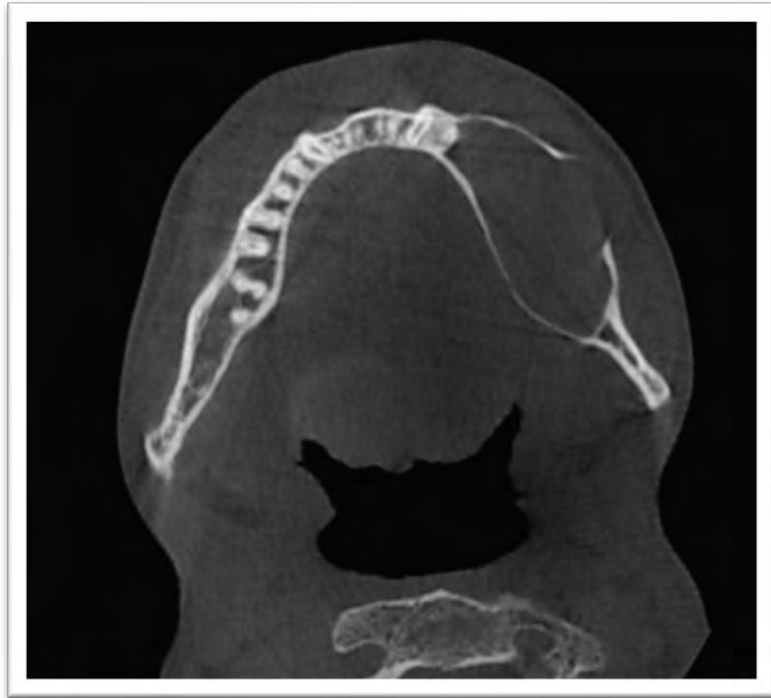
CT scan -preoperative showing cystic lesion.
